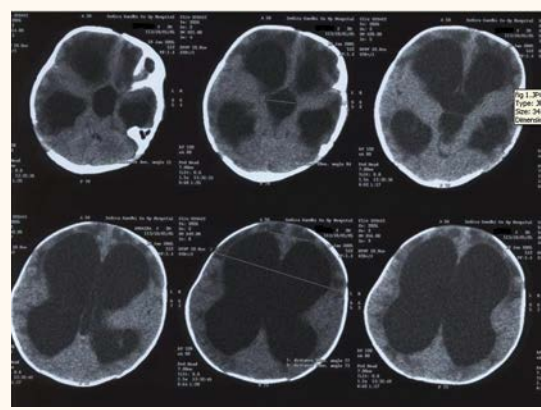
Initial computed tomography scan showing triventriculomegaly.
